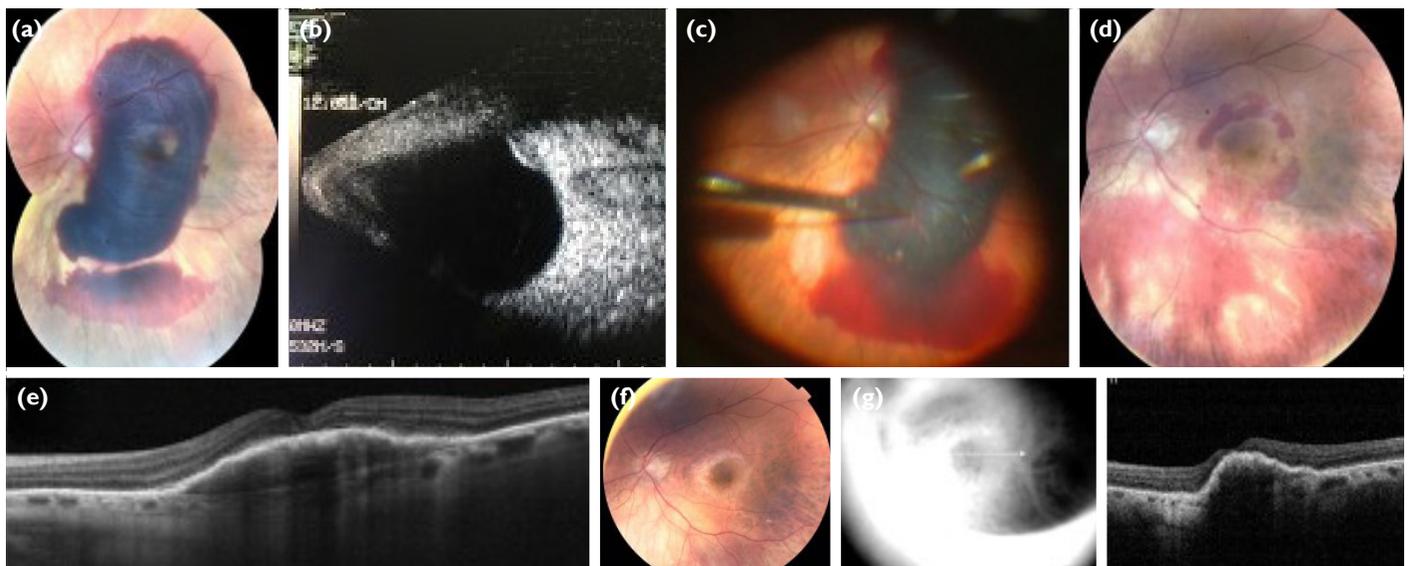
(Case-1) A 73-year-old male patient had a visual loss in his left eye for the past 4 days. His left vision is hand movements. (a) The appearance of large subretinal hemorrhage starting above the upper vascular arch and extending below the lower vascular arch in the left fundus image of the patient. (b) The appearance of the hemorrhage area in the macula in the horizontal section in the eye ultrasonography of the patient whose OCT image could not be obtained. (c) The subretinal tPA and bevacizumab injection appear in the intraoperative picture. (d and e) Fundus and OCT images were taken at postoperative 2nd week. The patient's visual acuity is 0.05 decimal in the left eye. (f and g) Post-operative 6th-month fundus and OCT images of the patient. Subretinal hemorrhage completely regressed, but retinal pigment epithelial (RPE) rupture due to recurrent bevacizumab injections is seen. Pigment epithelial detachment (PED) continues.
